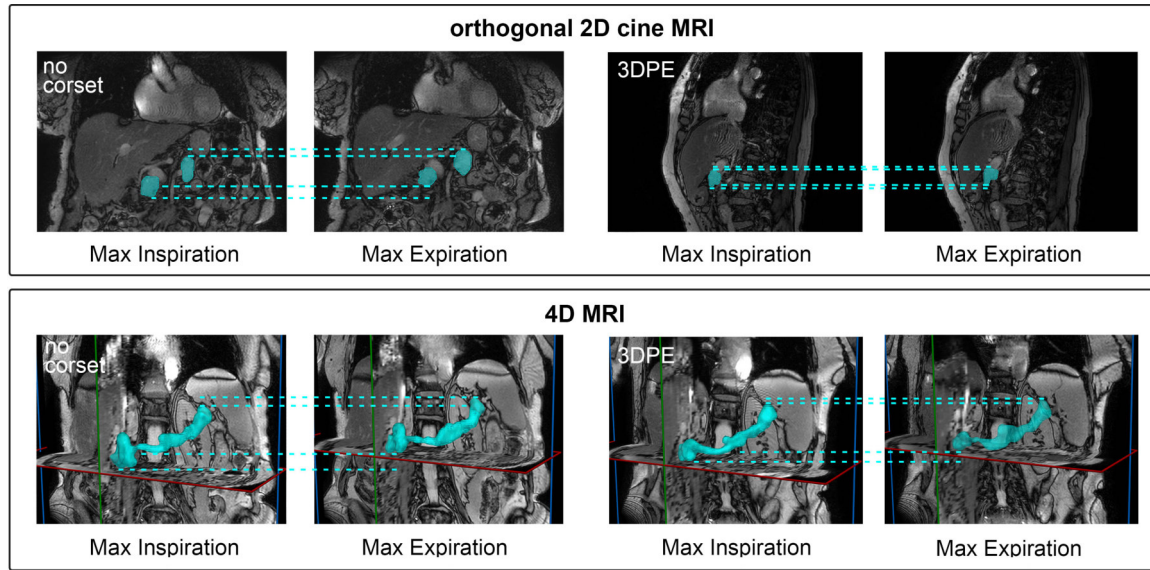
Orthogonal (coronal and sagittal) single-slice 2D-cine MRI (*top*) and 4D-MRI (*bottom*) of patient in free breathing (*left*) and wearing the 3DPE corset (*right*) showing the state of maximum expiration and inspiration. The pancreas is segmented and lines are added at the caudal and cranial edge of the pancreas to visualize the amount of pancreatic motion.
